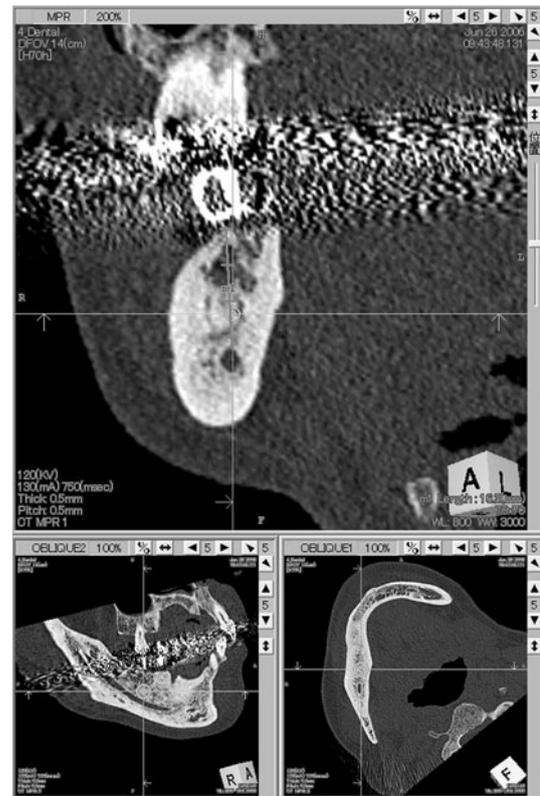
Measurement of linear distance on a CT image
